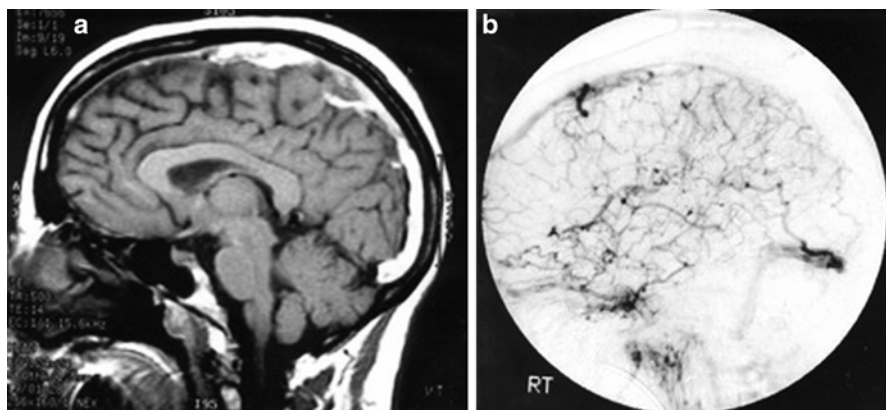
(a) Gadolinium-enhanced sagittal MRI showing thrombus within the superior sagittal sinus (SSS). (b) Lateral projection cerebral angiogram confirming SSS thrombosis and demonstrating the collateral venous drainage patterns
